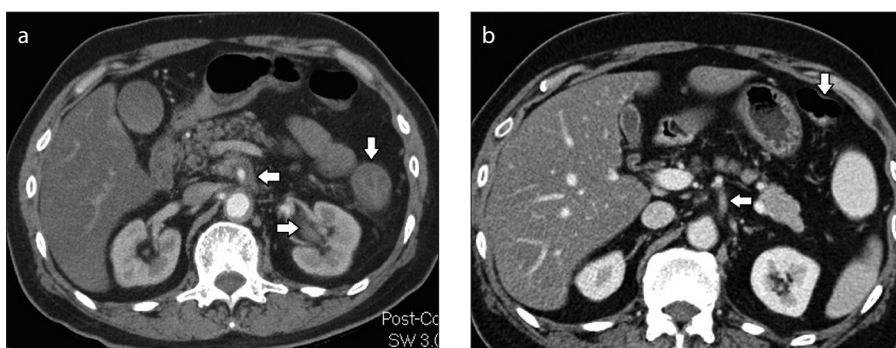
a, b. Axial CT image (a) through the upper abdomen shows soft tissue along the superior mesenteric artery (SMA) (*left arrow*). Also note inflammation around left renal pelvis (*right arrow*) and inflammatory changes in the descending colon (*down arrow*). Axial CT image (b) at a similar level shows resolution of soft tissue along the SMA after treatment with corticosteroids.
